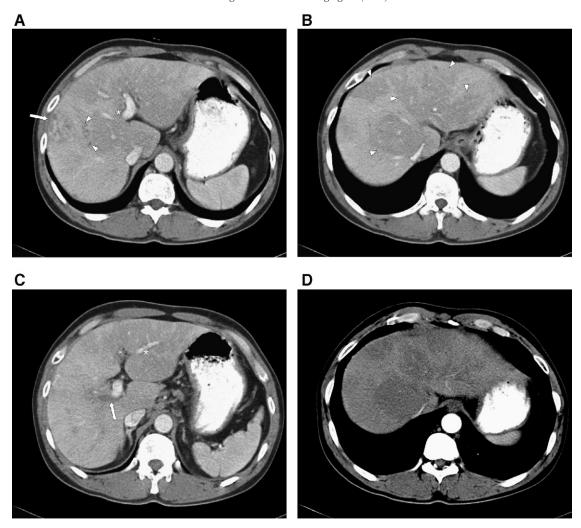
Contrast-enhanced CT images of the 50-year-old male patient's liver; (A–C) portal phase; (D) arterial phase. (A) Contrast-enhanced CT scans showing a 3.5-cm-sized heterogeneously enhancing mass in the right lobe of the liver (arrow) with mild capsular retraction and adjacent peripheral intrahepatic bile duct dilatation (arrowheads). (B) Multiple geographic patchy low attenuation lesions in both liver lobes encompassing the portal triad (arrowheads). (C) Thrombosed right portal and peripheral portal veins of the right lobe (arrow). (D) Geographic patchy low attenuation lesions on portal phase did not enhance on arterial phase either. (A–C). Thin linear area of low attenuation closely bordering the portal branch (asterisks).
